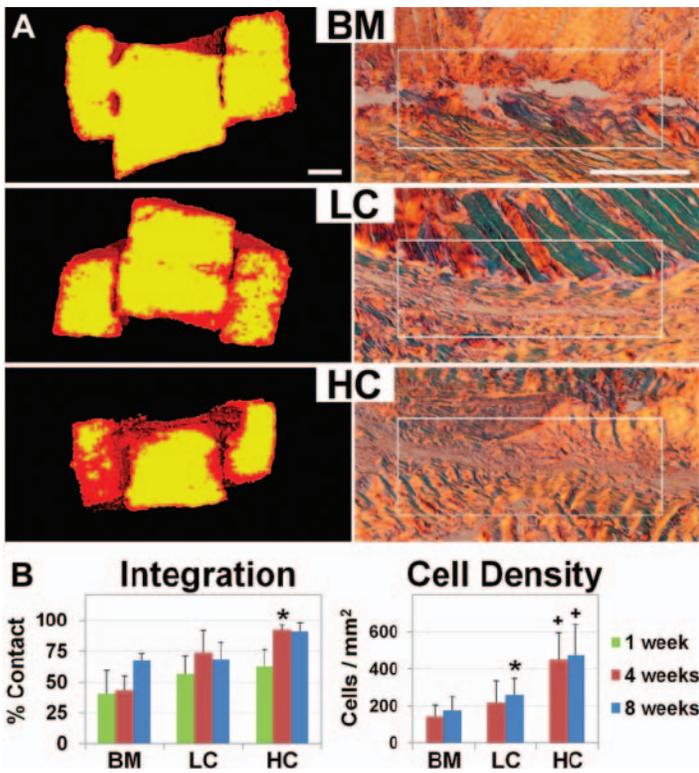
Changes with exposure to no (BM), low (LC), and high-dose (HC) collagenase. (A) Left: 1 week μ CT scans with low (red) and high (yellow) signal intensity. Scale = 1 mm. Right: 8 week PSR sections of the interface under polarized light. Scale = 0.25 mm. (B) Left: integration normalized to core perimeter. Right: cell density at the interface. * = $p \leq 0.05$ compared to BM. + = $p \leq 0.05$ compared to BM and LC.
